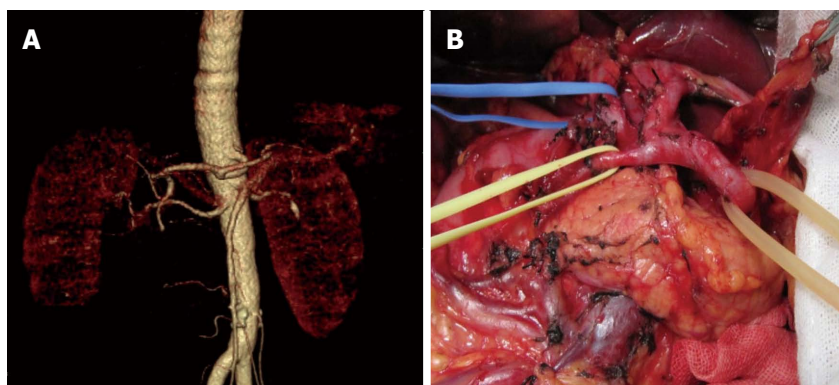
Normal celiac artery branches. A: Preoperative multi-slice computed tomography angiography: Normal celiac trunk gives off LGA, splenic artery and common hepatic artery; B: Intraoperative finding was consistent with preoperative findings.
